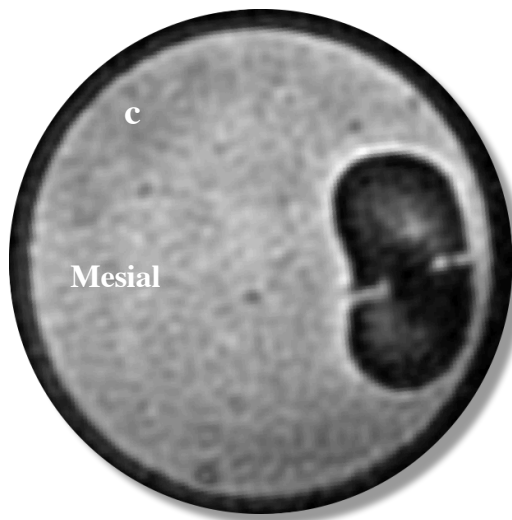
Maxillary 1st premolar with mesial and distal cracks. Selected corresponding axial slices: SWIFT MRI (c) with notable absence of metal streak artifact from amalgam core restoration, and limited FOV CBCT (d) with severe metal streak and beam-hardening artifacts.
